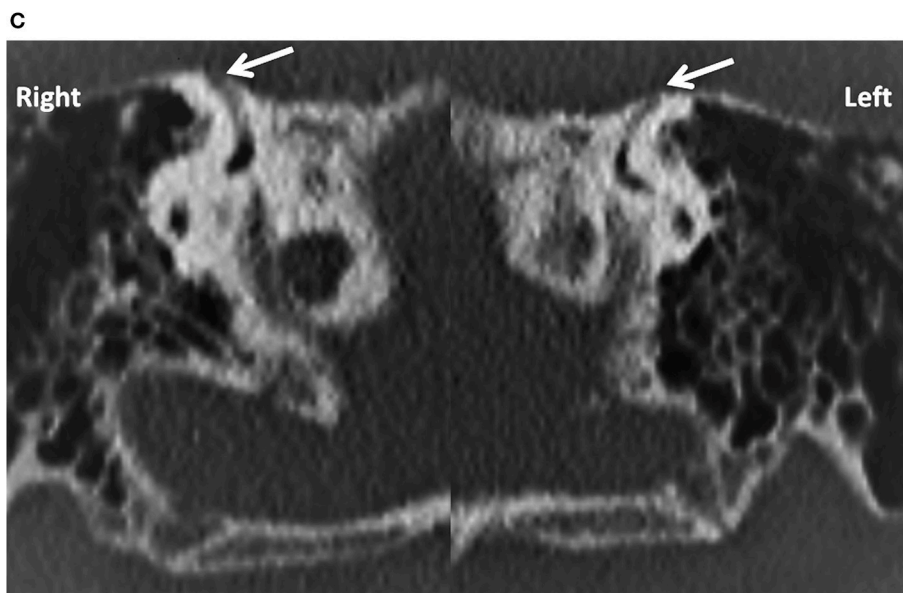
(A) PTA in child presenting with conductive dysacusis (child 7). (B) Video head impulse test in a child with covert saccades in the right superior semicircular canal (arrow). (C) Coronal reconstruction of High resolution CT scan shows dehiscence of the superior semicircular canal on both sides (arrows).
